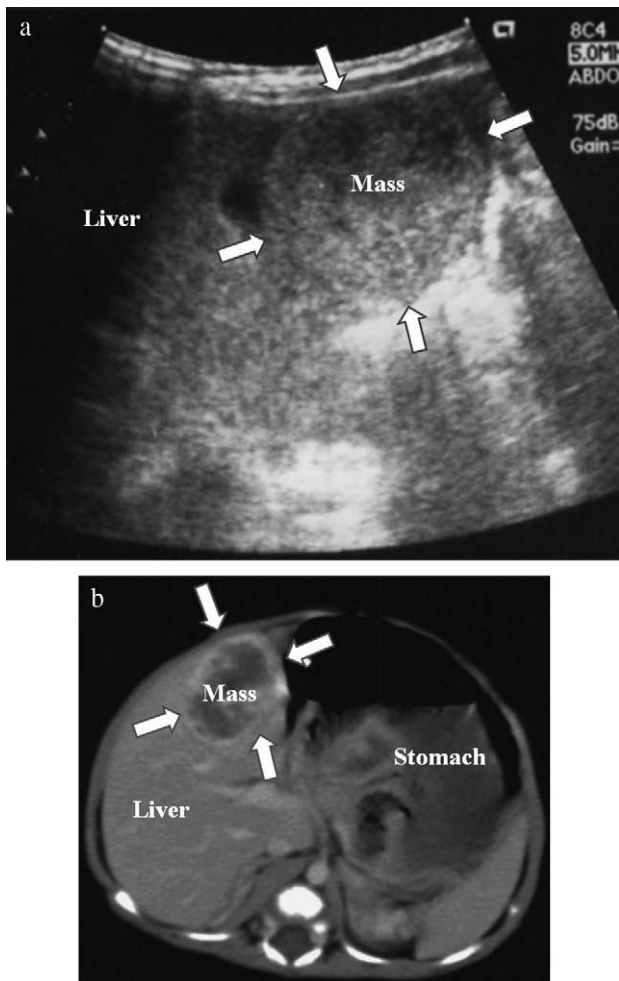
Hepatic hemangioendothelioma. (a) A well-defined heterogeneous parenchymal tumor was identified on ultrasonography. (b) The tumor was a ring-enhanced hypervascular tumor with minimal feeding and drainage vessels. A diagnosis of hepatic hemangioendothelioma was made.
